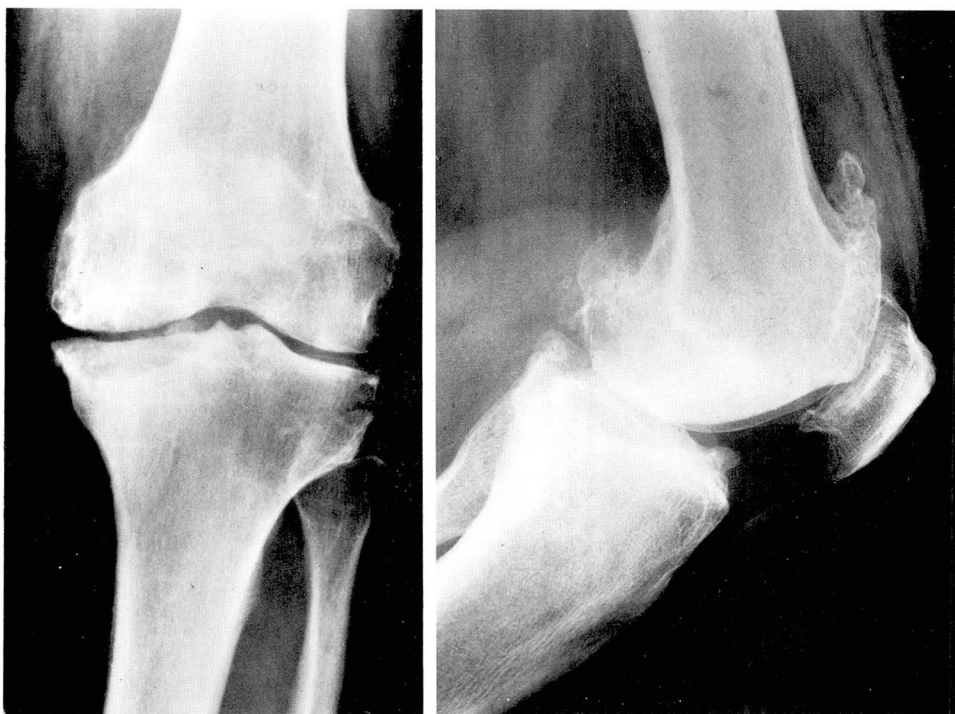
Anteroposterior and true lateral roentgenograms of the left knee joint demonstrating osteoarthritic changes consisting of osteophytes at the margins of the femur, tibia, and patella. There is depression of the medial tibial plateau and sclerosis of bone beneath the joint surfaces.
